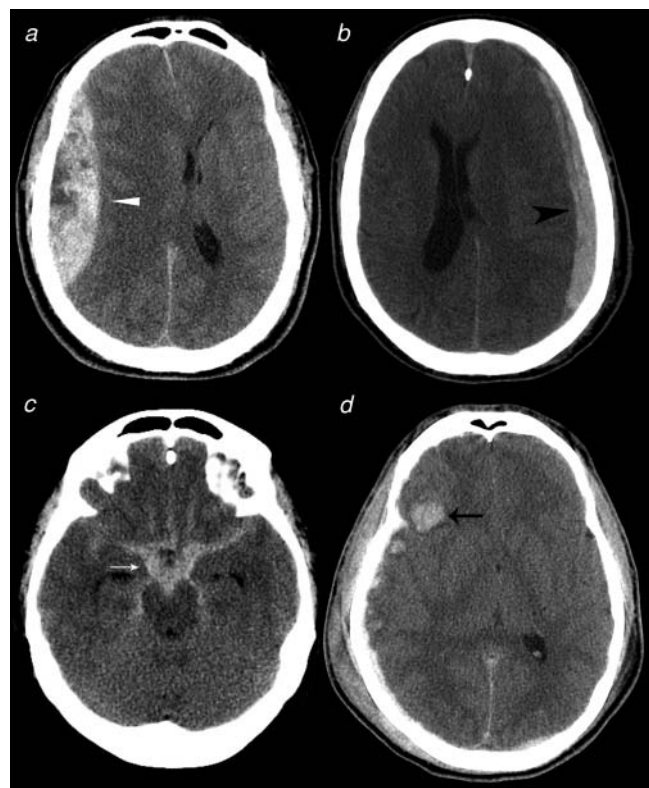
Head computed tomography remains the initial imaging test of choice for detection of acute intracranial bleeding, which may occur in the epidural space (a, epidural hematoma, *white arrowhead*), the subdural space (b, subdural hematoma, *black arrowhead*), the subarachnoid space (c, subarachnoid hemorrhage, *white arrow*), within the brain parenchyma (d, hemorrhagic contusion, *black arrow*), or any combination of the above.
